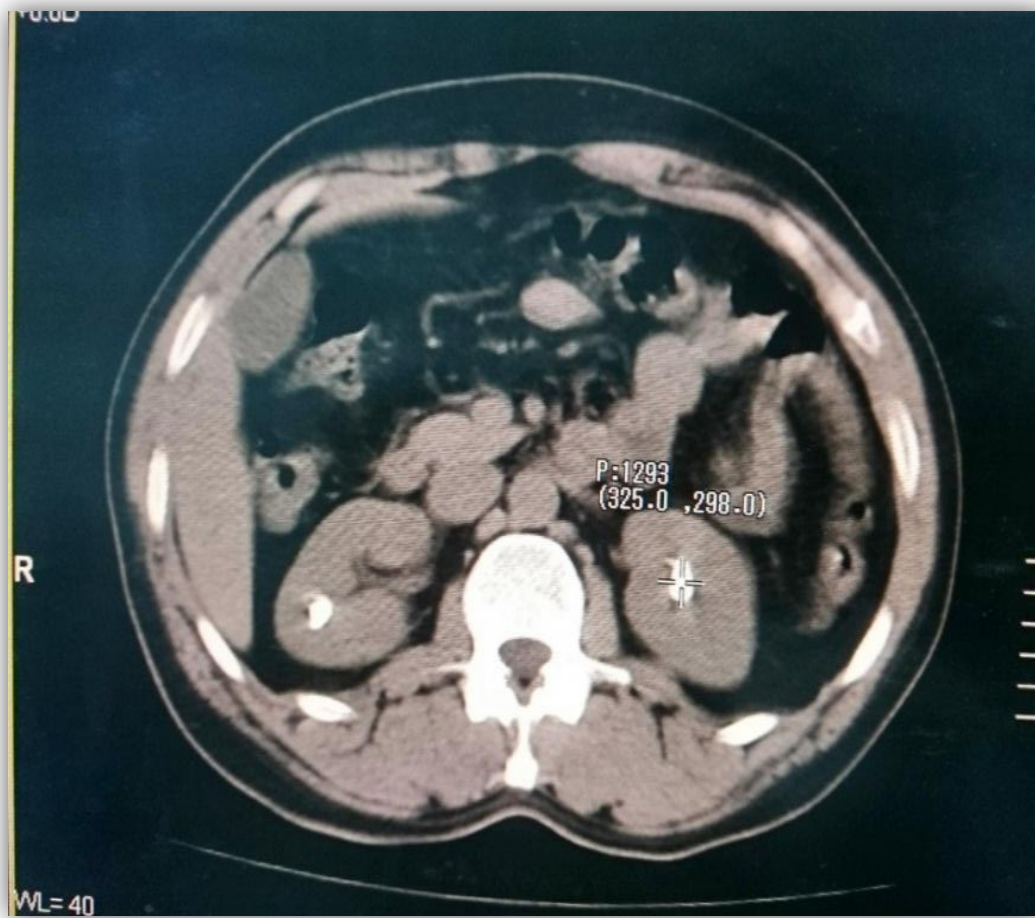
represent the CT –KUB to same patient in previous image.
